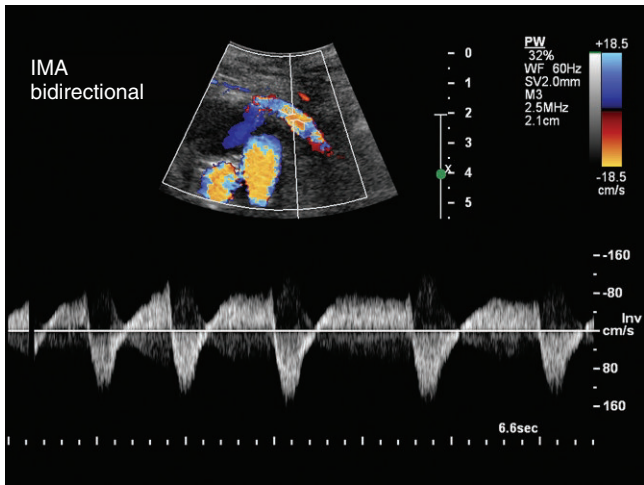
Doppler ultrasound of the inferior mesenteric artery demonstrates bidirectional flow within that artery that supplies the abdominal aortic sac.
